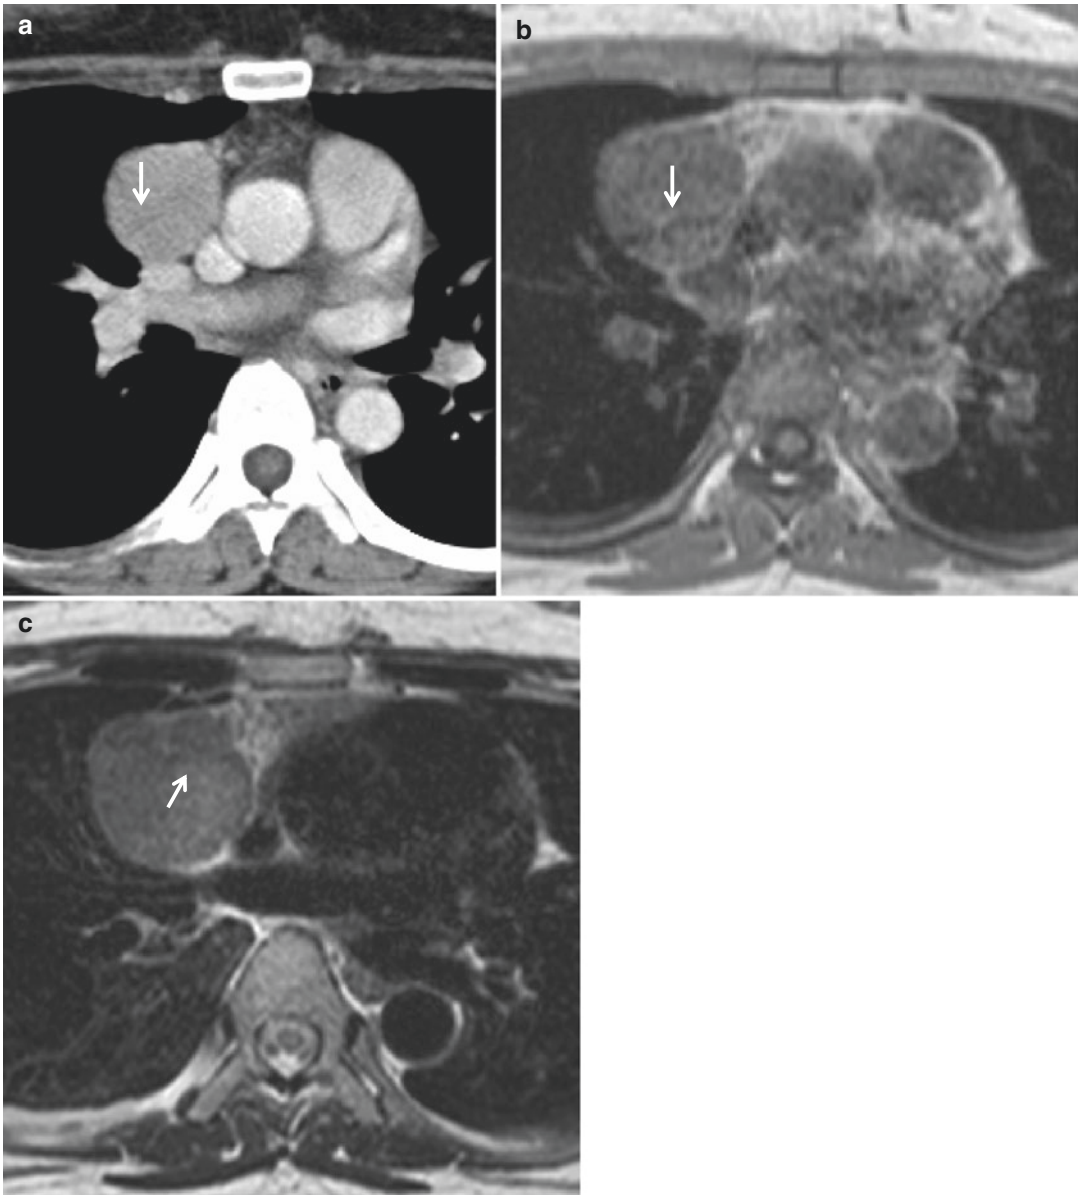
Noninvasive thymoma. (a) Contrast-enhanced CT, (b) T1-weighted, and (c) T2-weighted MR images show a well-defined mass in the anterior mediastinum with a fibrous capsule and septae (*arrows*), characteristic of thymoma
